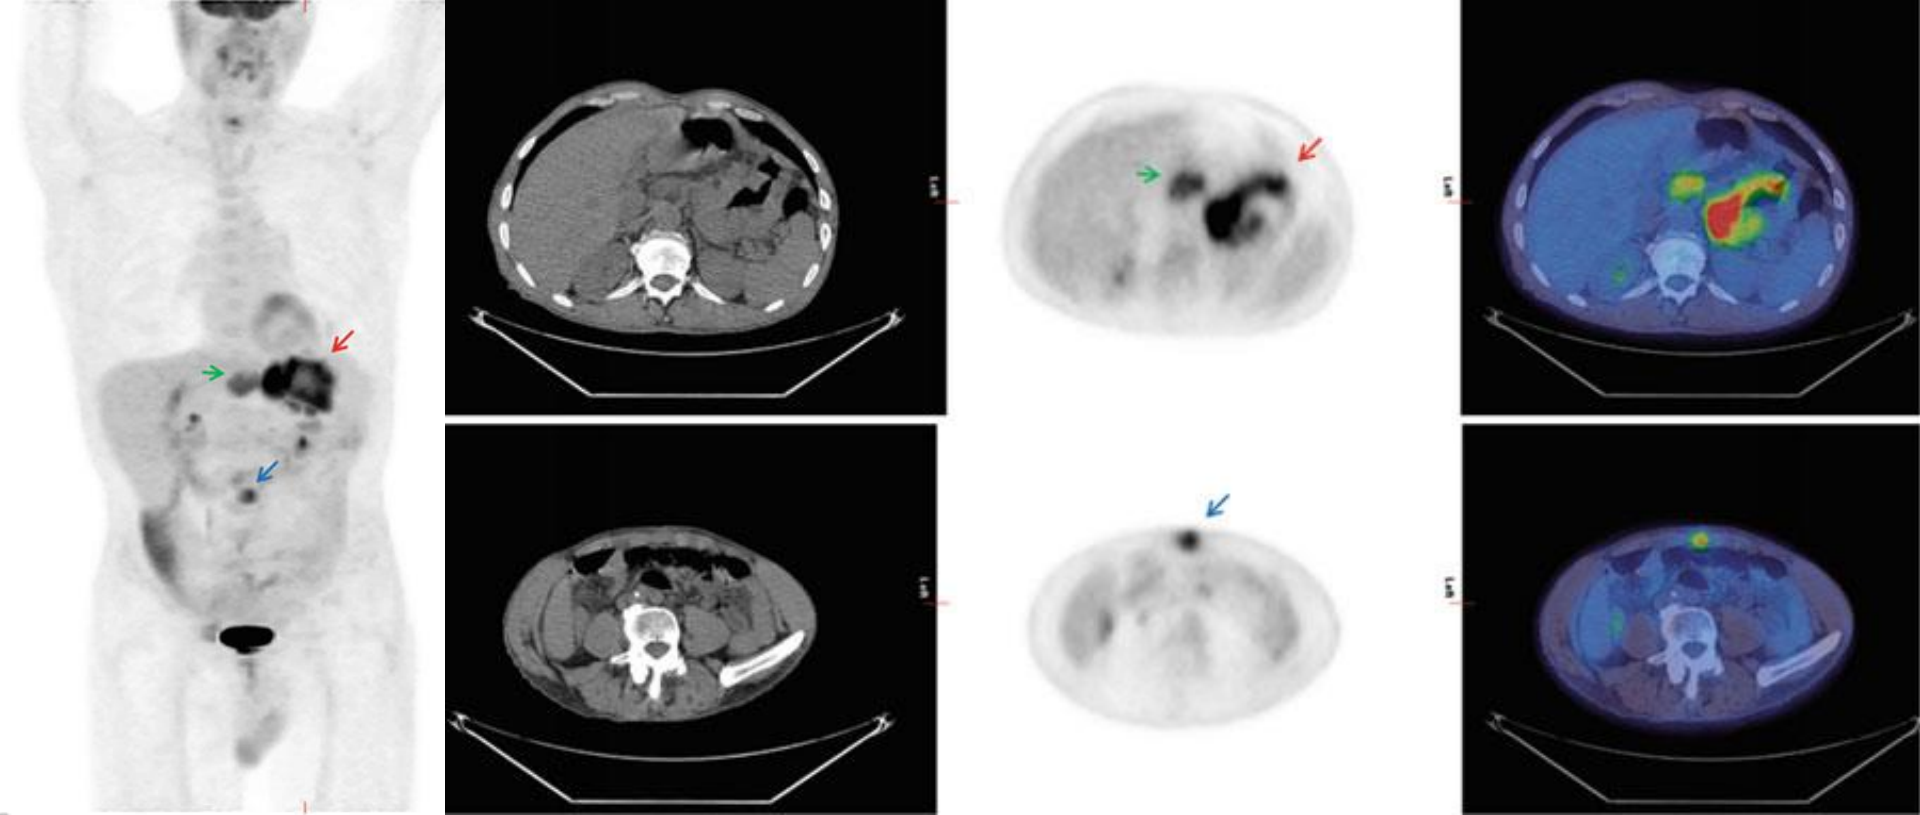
(a) MIP image; (b , c) axial images of low-dose CT, PET and fused PET-CT. There is intensely increased tracer uptake (SUV max = 7.1) within the large gastric tumour centred on the lesser curve of the stomach (a , b , *red arrow*). There are FDG-avid left gastric nodes (a , b *green arrow*). In the midline anterior abdominal wall, there is a focus of high uptake (a , c *blue arrow*) corresponding to soft tissue thickening on the CT component
